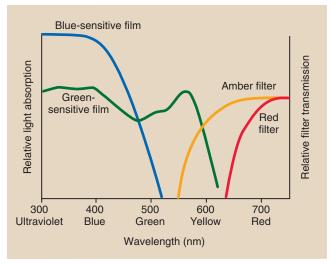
Radiographic films are blue sensitive or green sensitive, and they require amber- and red-filtered safelights, respectively.
